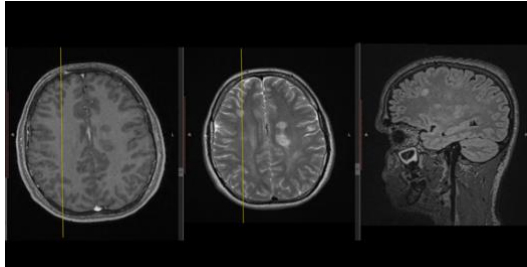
First non-specific patient, former MRI. T1-contrast-enhanced (left image) and T1-native (middle image) cerebral MRI images: black holes can be observed, depicting the degenerative process of multiple sclerosis. Source: Author's elaboration.
